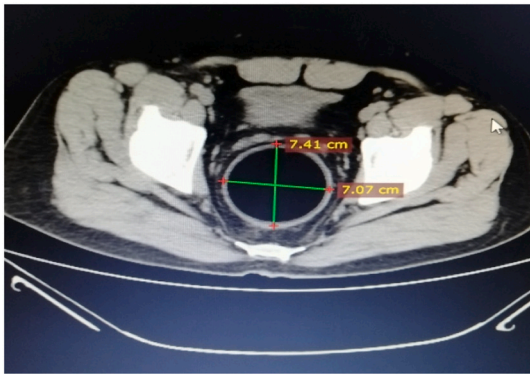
Abdominal CT scan showing a 7 × 7 cm ball impacted in rectum.
